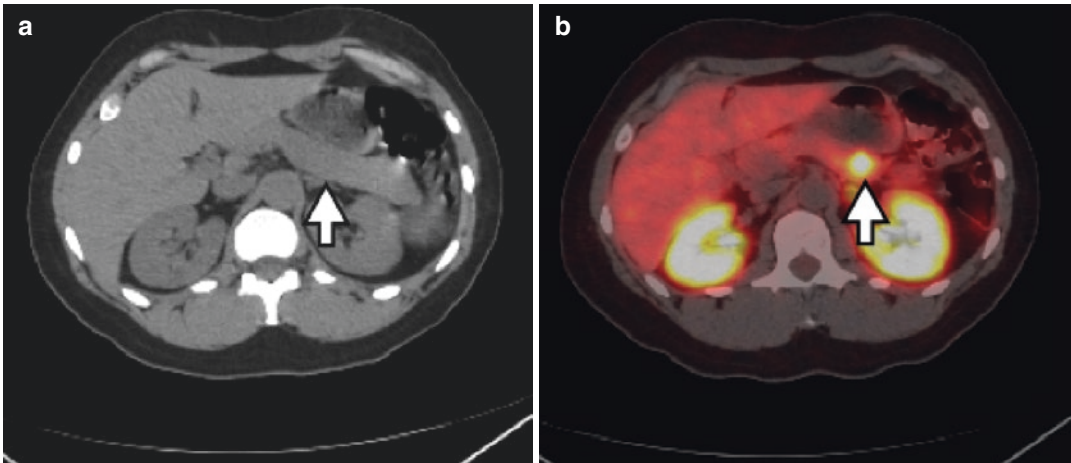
PET/CT. DOTATATE PET/CT of a patient with suspected neuroendocrine tumor due to multiple endocrine neoplasia (MEN) type 1. Non-contrast CT at the level of the pancreas (arrow), without an obvious
